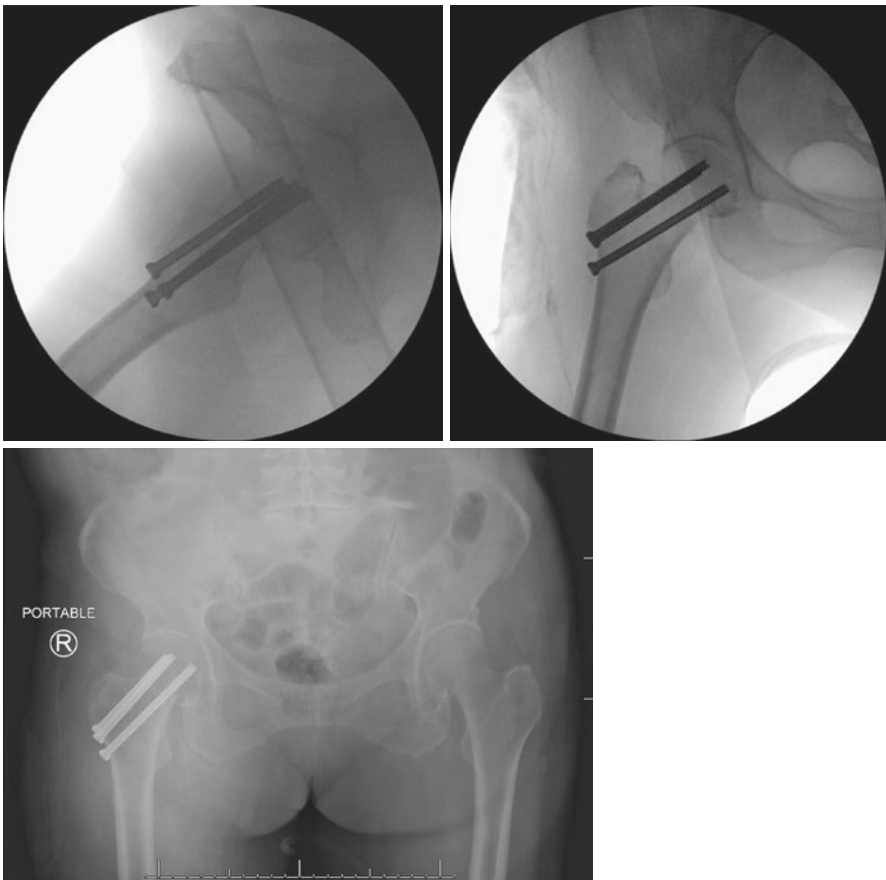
Postoperative X-rays following closed reduction percutaneous pinning
